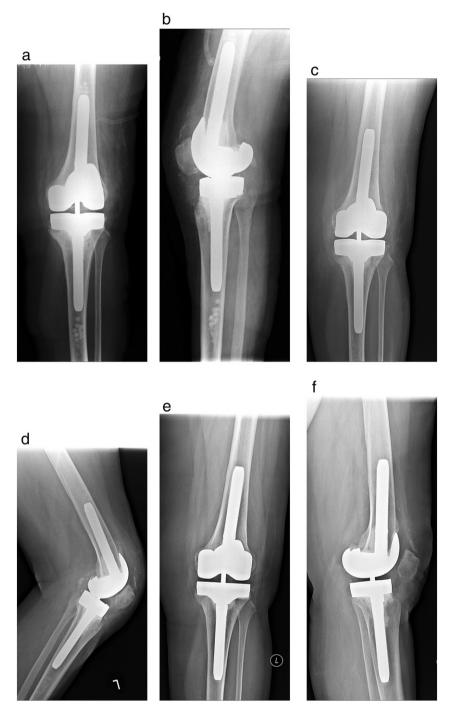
Radiographs of patient after revision TKA for PJI. No postoperative XR beads of Herafill can be easily seen (a and b). At three months there is some resorption (c and d). At last followup, Herafill beads are integrated with the host bone.
